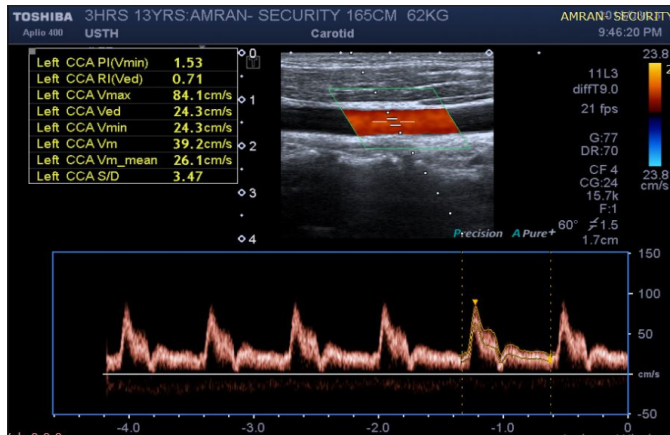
Doppler interrogation of Lt CCA hemodynamics for a Khat chewer participant has a 13 year period of chewing
